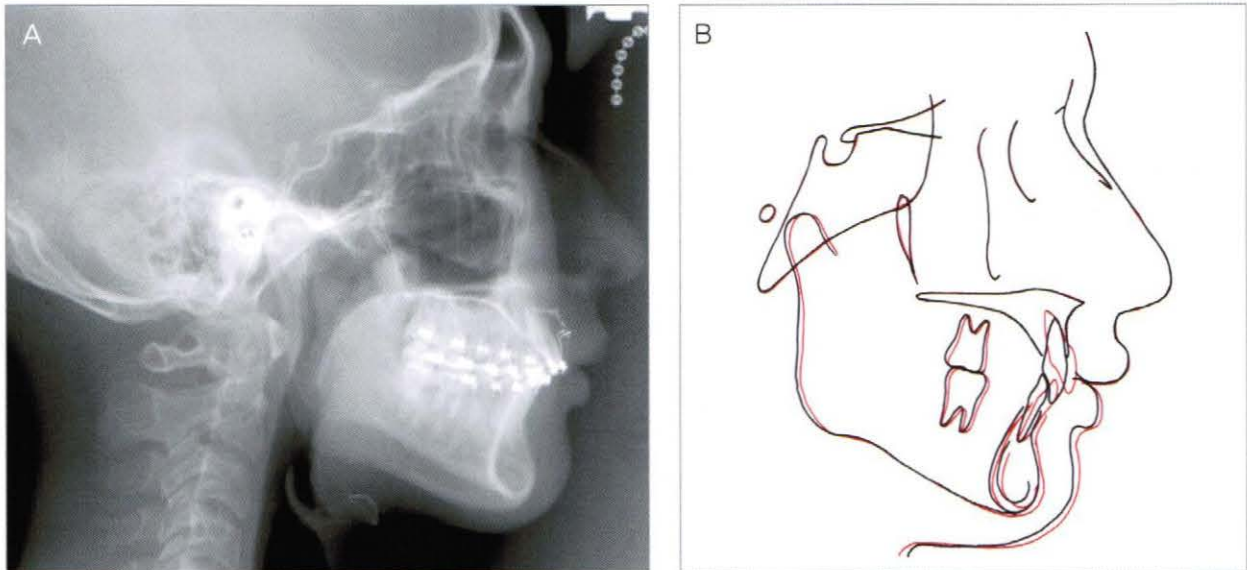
Eight months after upper incisor intrusion (2006, 4,5), cephalometric radiograph and measurement.
